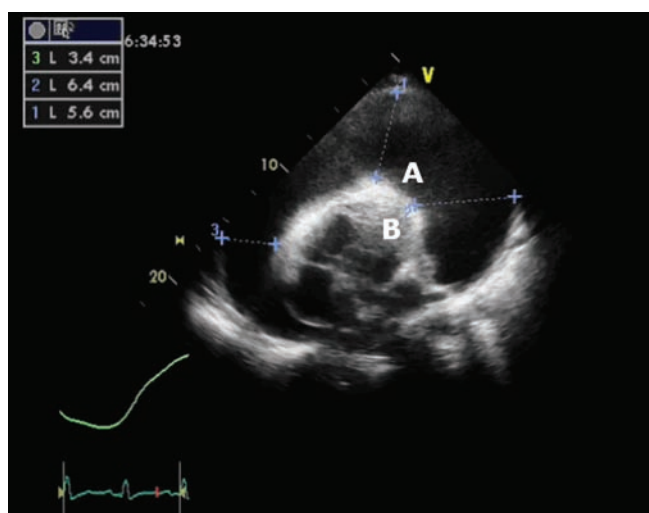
An apical four-chamber echocardiographic view demonstrating a significant pericardial effusion (A), measuring 6.4 cm in depth. The heart was seen 'swinging' in the centre (B).
